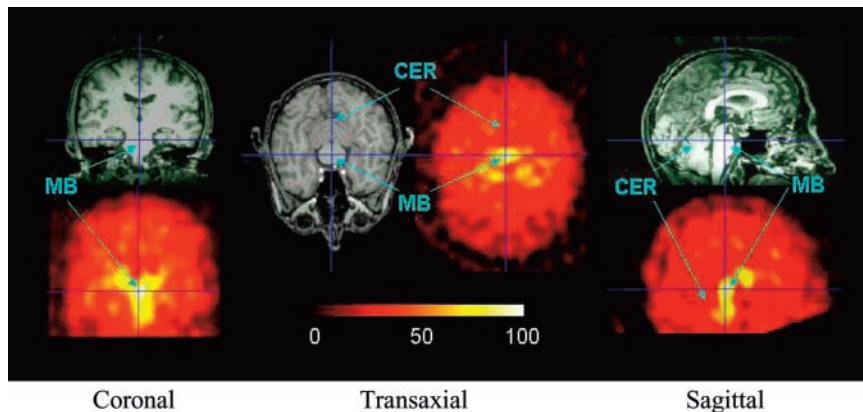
SPECT scans of brain acquired 3 h after administration of ^{123}I -ADAM and compared with comparable MR images. MB = midbrain; CER = cerebellum.
